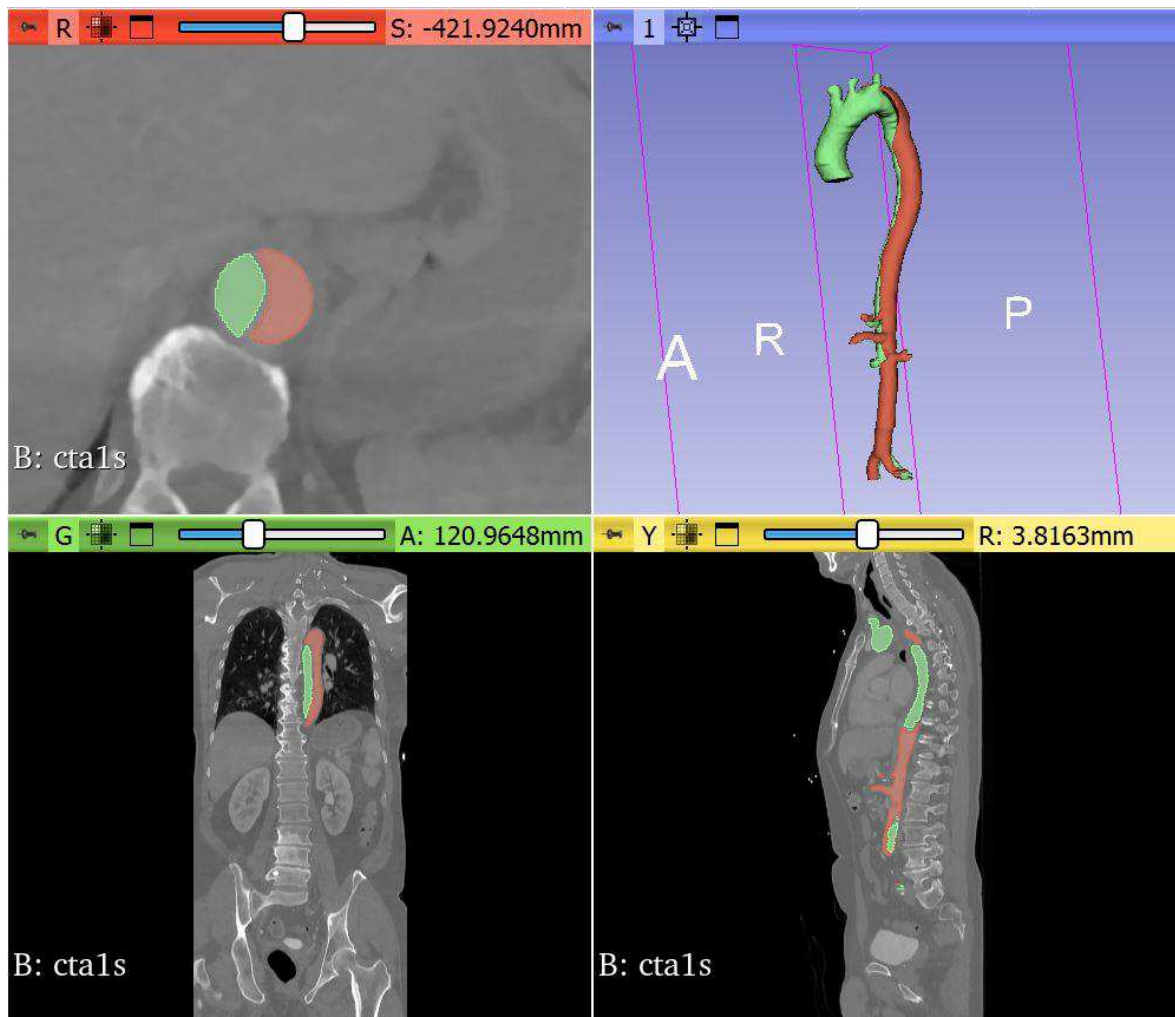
4 window view of CTA 1 in the program “3D Slicer, showing the CTA scan in horizontal (red), frontal (green), sagittal (yellow) plane and the final segmentation (blue), source: screenshot from “3DSlicer” by author
